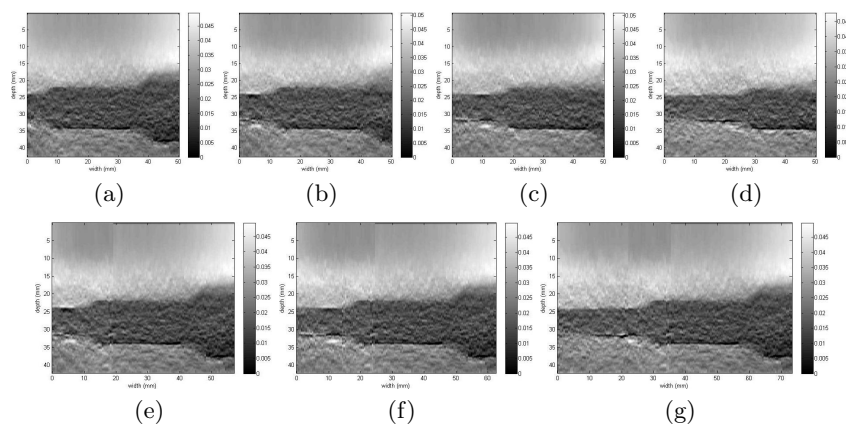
Ultrasound elastography at position t_0 (a), t_1 (b), t_2 (c), t_3 (d) and elastography mosaic of positions t_0 and t_1 (e), t_0 , t_1 and t_2 (f), and t_0 , t_1 , t_2 and t_3 (g).
